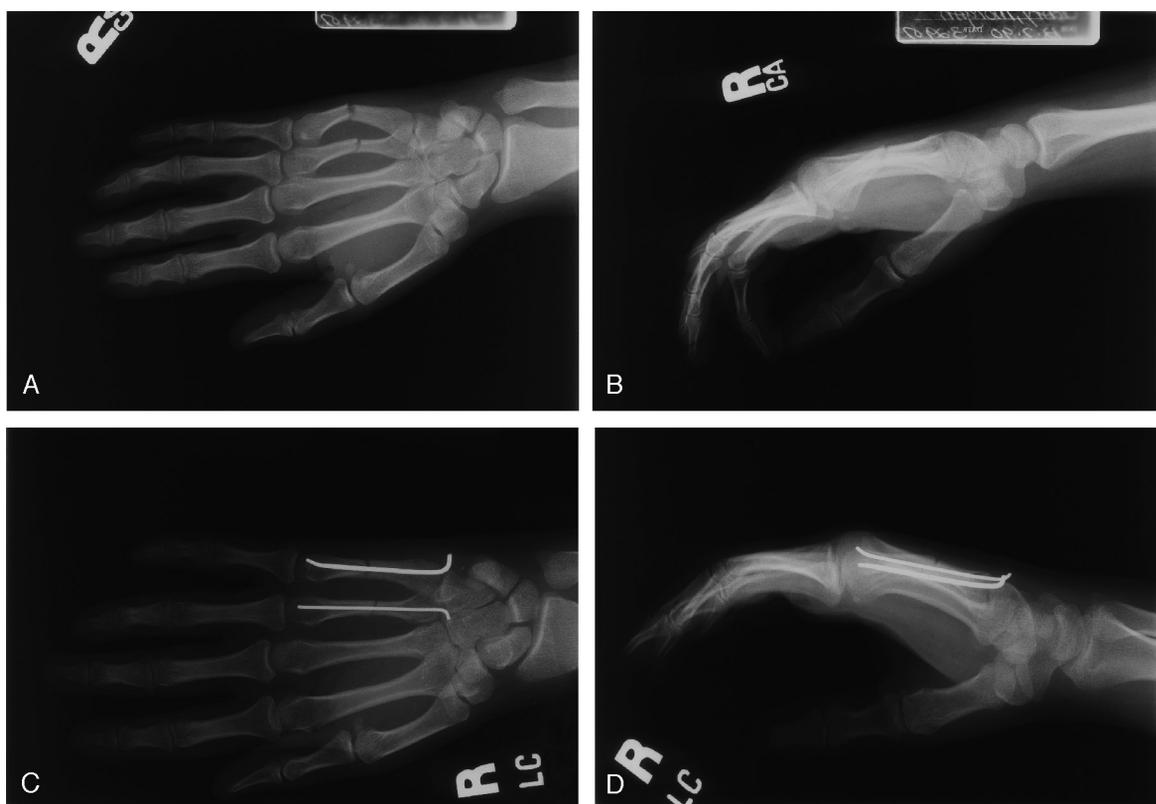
A and B, Preoperative radiographs. Fractures of ring and small finger metacarpals are demonstrated; note dorsal angulation. This small angulation was not apparent on inspection of the hand. C and D, Postoperative reduction films. The clinical deformity is resolved.
